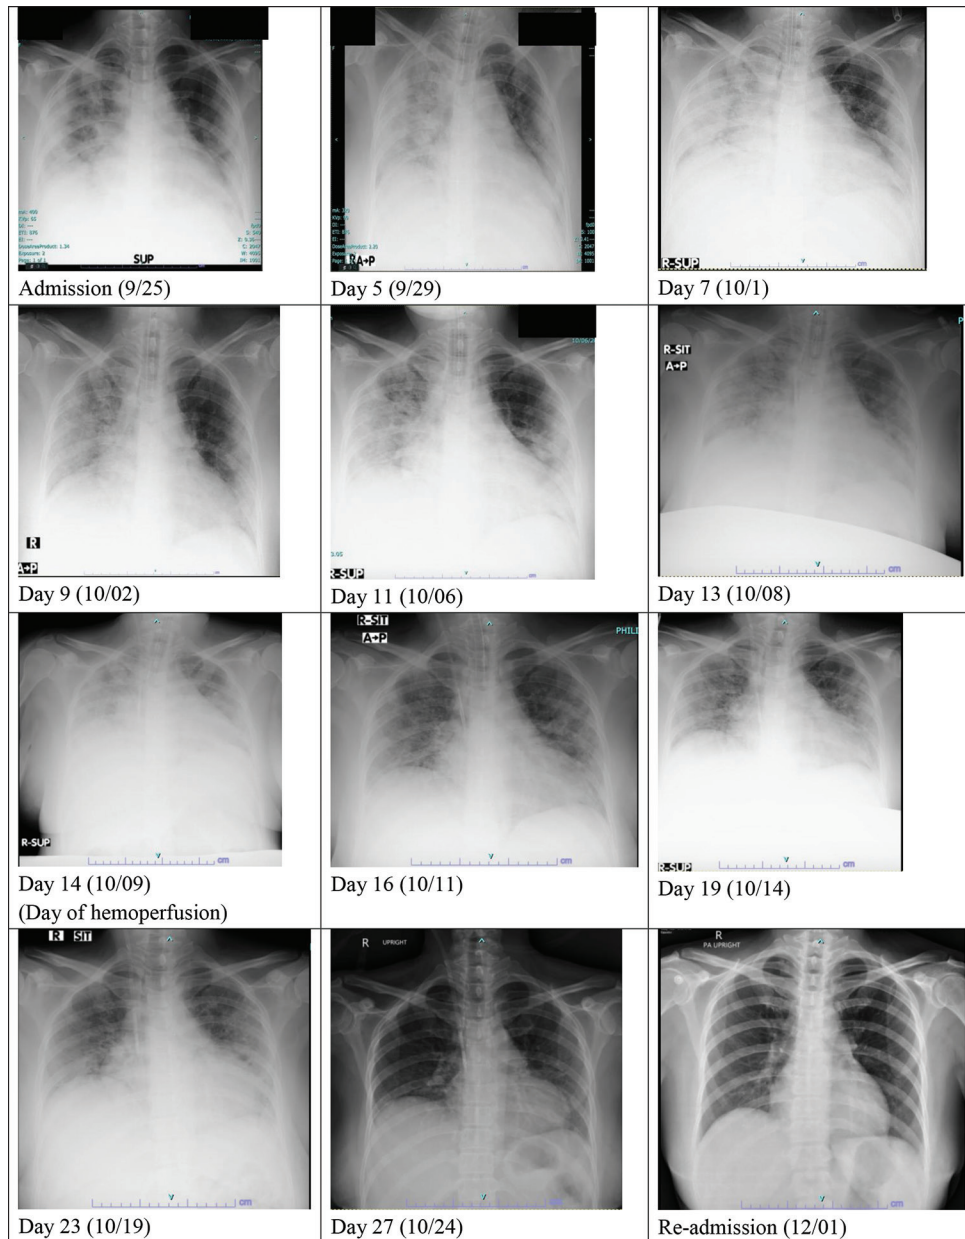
Serial Chest X-ray examinations
